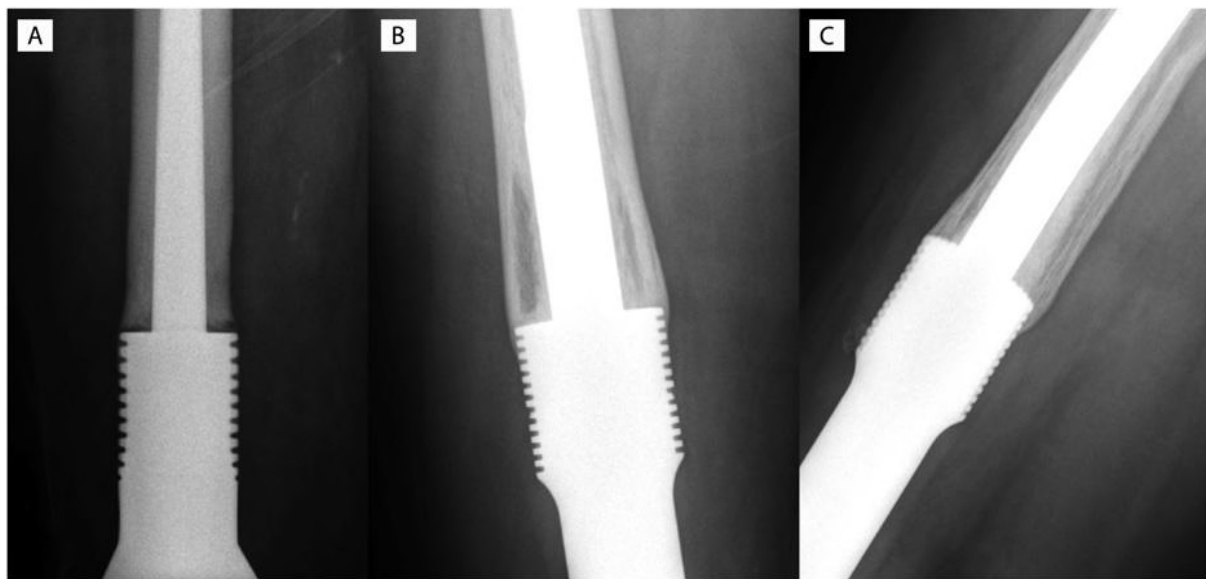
An anteroposterior radiograph of a distal femoral prosthesis fifteen years after it was inserted to treat malignant fibrous histiocytoma in a forty-three-year-old female patient. No extra-cortical bone growth into the hydroxyapatite-coated collar is seen (and none was seen on the mediolateral radiograph), and the score for osseous ingrowth was 0. Figure. 2.2-B An anteroposterior radiograph of a distal femoral prosthesis eleven years after it was inserted to treat osteosarcoma in a twenty-seven-year-old man. Bone growth over the collar is seen in both the anterior and posterior regions, resulting in a score of 2. When that score was combined with a score of 1 derived from the lateral radiograph (Figure 2.2-C), this patient received a total score of 3 for osseous ingrowth.
